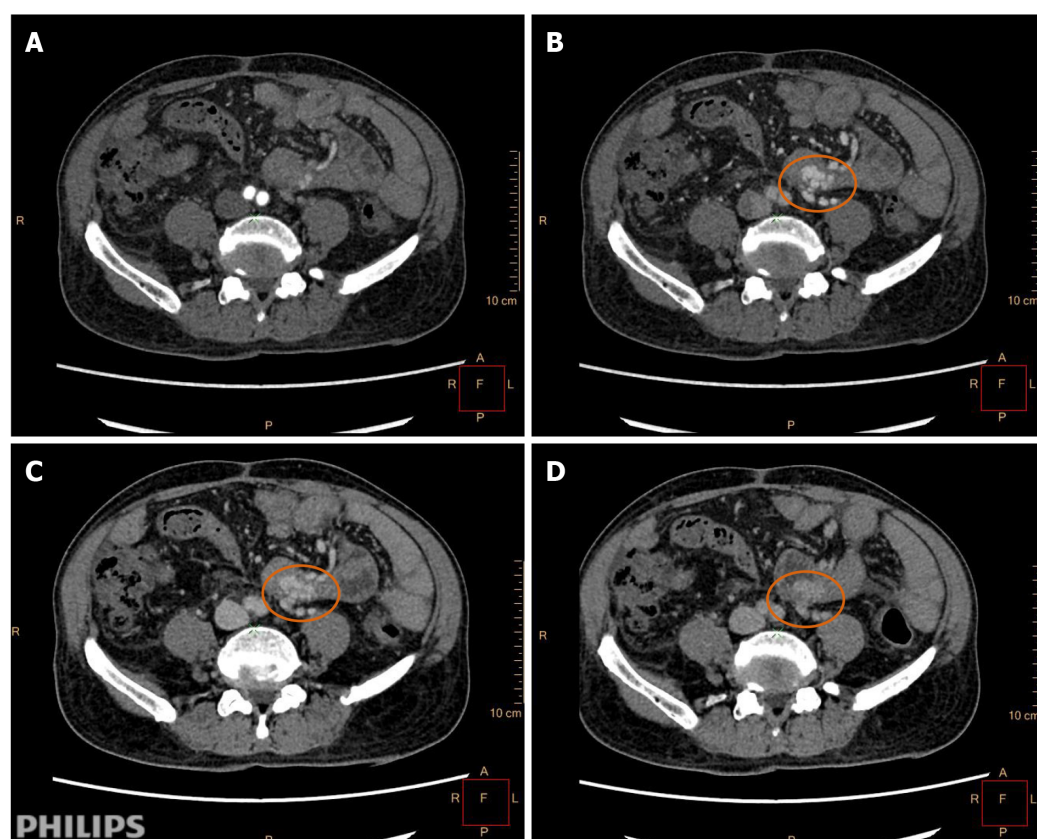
Four-phase dynamic computed tomography features and identifying the bleeding in arterial-phase, portal-phase, equilibrium-phase, and delayed-phase scanning. A: The arterial-phase showed no abnormal signs of the blood vessel on computed tomography images; B: During the portal-phase, the testicular vein and the superior mesenteric vein gathered together with vascular dilatation, tortuosity, and active bleeding (orange circle); C: The equilibrium-phase also showed bleeding; and D: Delayed-phase scanning showed vascular mass enlargement.
